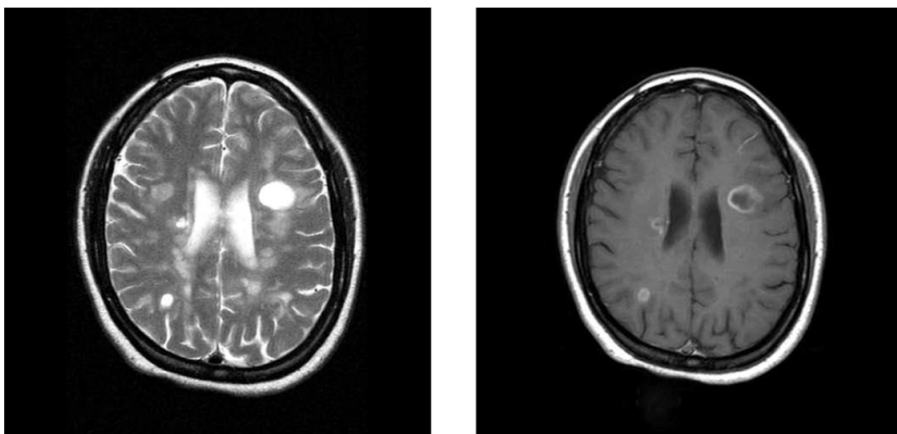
Comparison of a typical T2w (left) with a T1w+Gd (right) MR images showing MS lesions in periventricular areas of white matter. In the T1w+Gd image, the juxtacortical location and enhancement are suggestive of active lesions [Price, 2009]. Both images display only the transverse plane.
